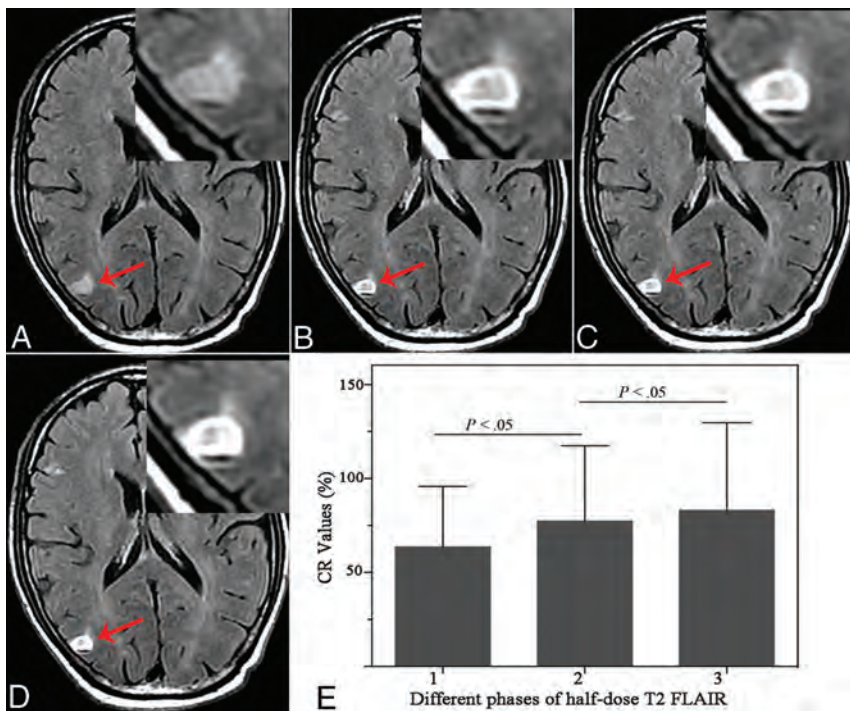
A 64-year-old man with brain metastases in the right parietal cortex (arrow). A, Nonenhanced T2 FLAIR. B, Phase 1: half-dose CE-T2 FLAIR shows a ring-enhancing lesion. C, Phase 2: half-dose CE-T2 FLAIR at 2 minutes 49 seconds. D, Phase 3: half-dose CE-T2 FLAIR at 5 minutes 38 seconds. E, The CR value of the ring wall on T2 FLAIR shows a tendency toward an increase with delayed scanning time.
